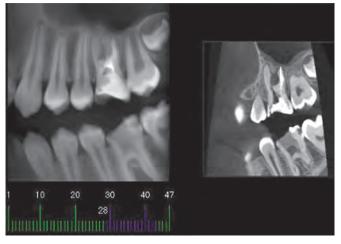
Initial CBCT scan for root resection planning.
